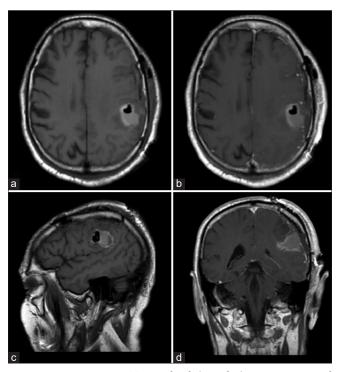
Postoperative T1-weighted (a and c) pre-contrast and (b and d) post-contrast magnetic resonance imaging demonstrating complete removal of the contrast-enhancing tumor.
